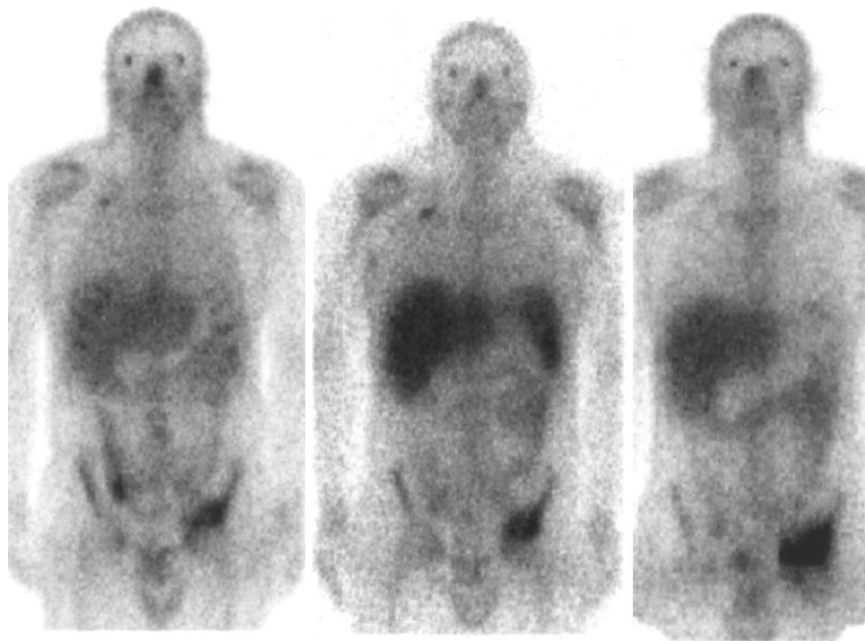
Abnormal ^{67}Ga scintigraphy findings during and after chemotherapy in 33-y-old man with biopsy-proven recurrent HD involving left acetabulum. ^{67}Ga scintigraphy before treatment (left) shows area of pathologic uptake in left acetabulum. Chemotherapy including dexamethasone, ifosfamide, cisplatin, and etoposide was initiated. ^{67}Ga scintigraphy during treatment (center) and at completion of chemotherapy (right) shows increase in size and intensity of pathologic uptake. Repeated bone biopsy indicated presence of active HD. (Note also abnormal ^{67}Ga uptake in involved right supraclavicular lymph node.) Tumor progression was diagnosed, and patient died 6 mo later.
